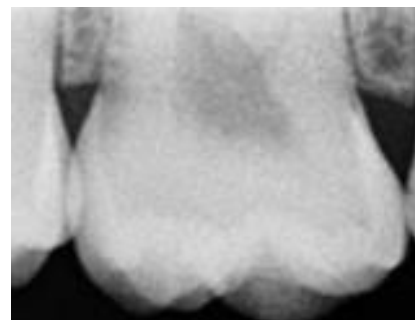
Bitewing radiograph of upper right 6 (16) see in Figure 3, suggesting the presence of dentine caries in the occlusal palatal fissure
